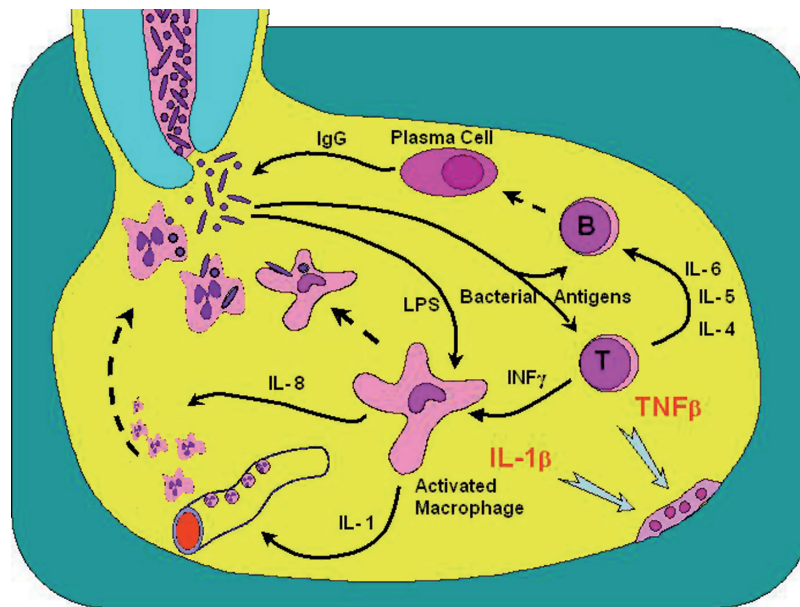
Protective functions of T lymphocytes and macrophages in the periapical granuloma. Specifically activated T lymphocytes produce a plethora of cytokines, some of which promote activation, proliferation, and maturation of B lymphocytes to become plasma cells producing immunoglobulins specific to the root canal bacteria. Macrophage activation is mediated by interferon- γ ($INF-\gamma$) produced also by these cells. Activated macrophages produce IL-1 and IL-8 that are essential for effective local recruitment and activation of PMNs. Bacterial endotoxin (LPS) can bypass the T lymphocytes and directly activate macrophages. Bone resorption in apical granuloma is mediated by IL-1 β (an activated macrophage product) and by TNF- β (an activated T lymphocyte product). It may be considered a negative side effect of the ongoing protective process in the apical granuloma.
